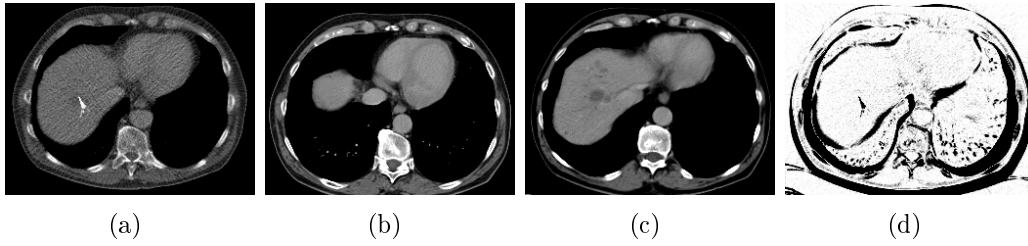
2D views (M-estimator). (a) shows a 2D CT synthetic slice including deformation, noise and needle. (b) shows the same axial position in the pre-interventional volume as the position where the synthetic slice was extracted in the deformed volume. This position is used as starting position for optimization. (c) shows the estimated minimum. (d) shows the weights image in the estimated minimum.
